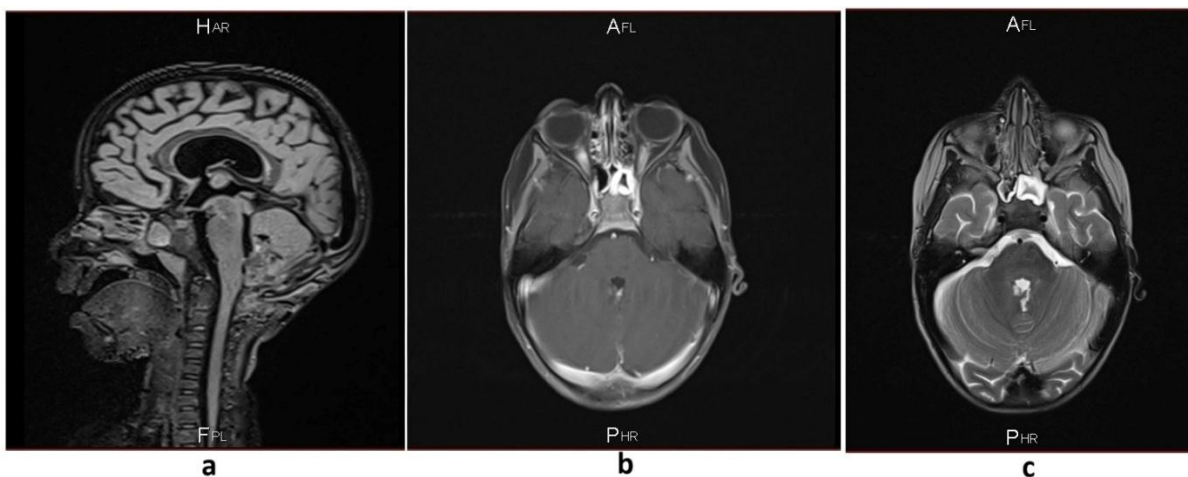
Postoperative brain MRI showing no residual tumor in Flair (a), T1 with gadolinium injection (b) and T2 (c) sequences
